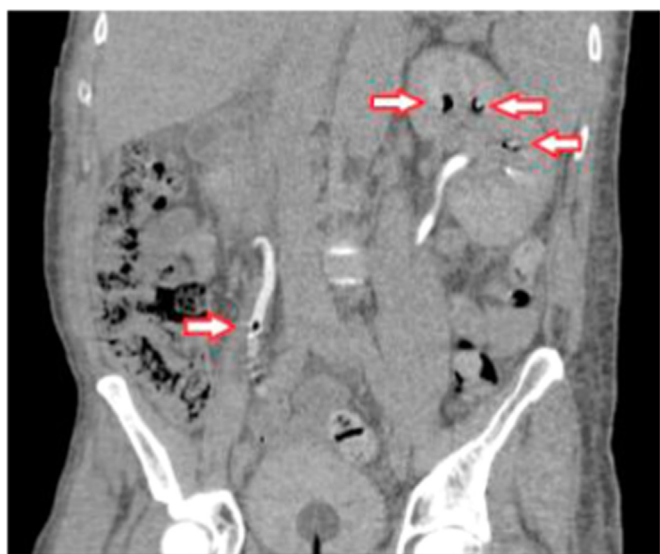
Follow up CT abdomen showing air in the left collecting system and right ureter.
